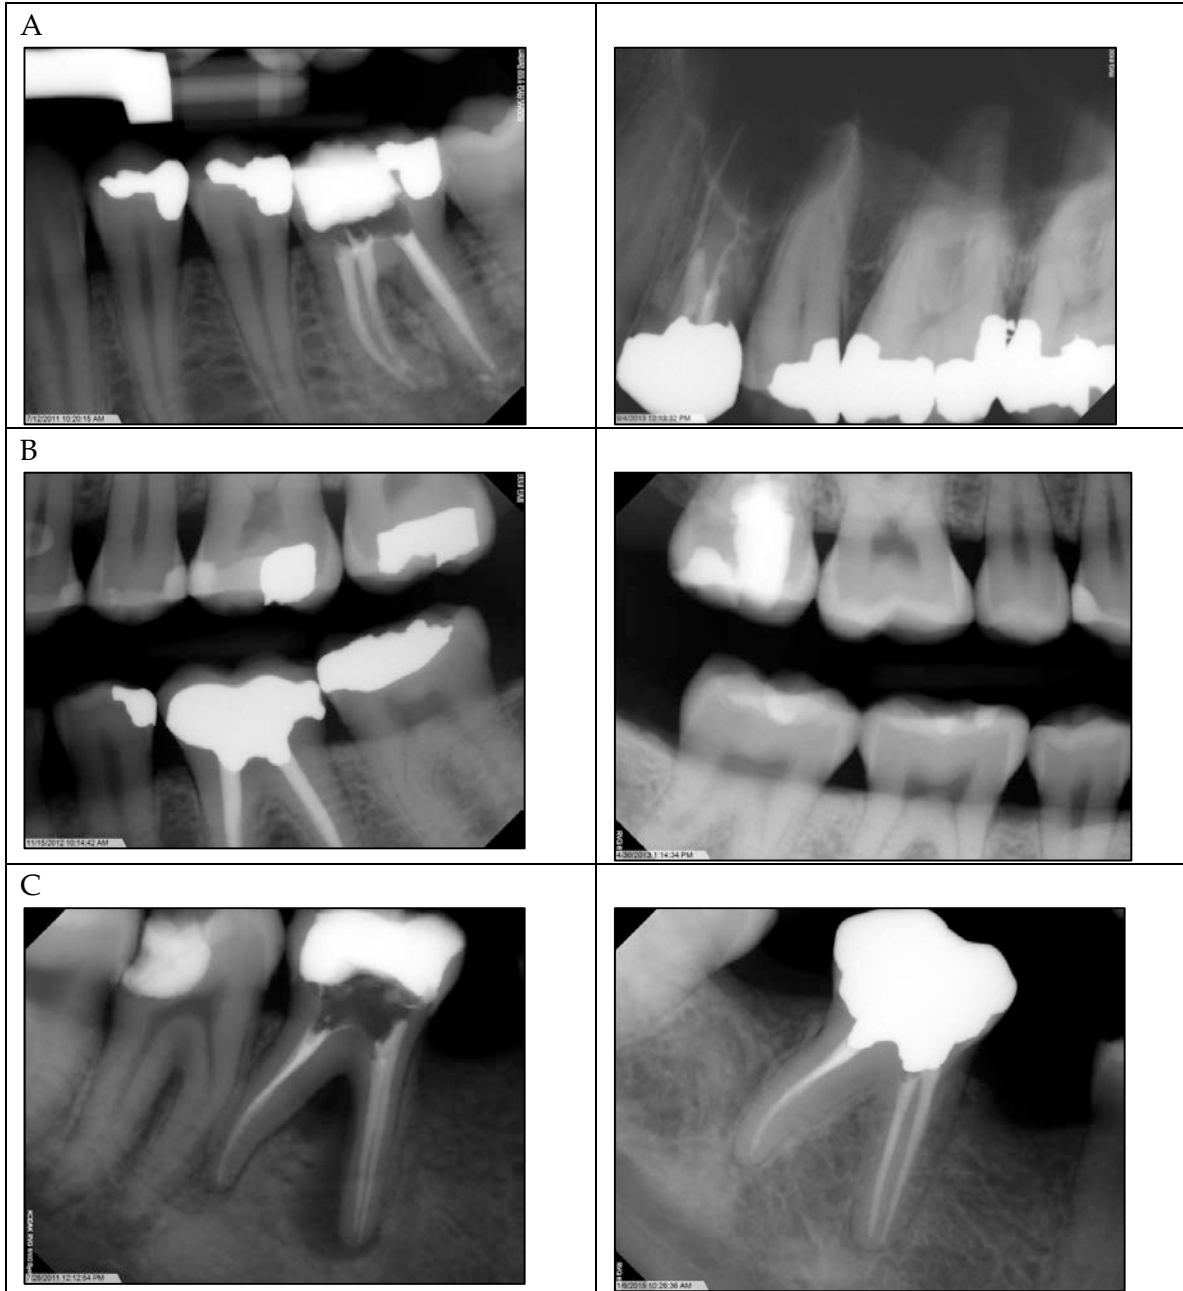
Represents examples of teeth deemed to have (A) adequate (left) and inadequate (right) RCT obturation, (B) adequate (left) and inadequate (right) cuspal coverage restorations, and (C) RCT teeth with periapical pathology present (left) and absent at 42 month recall (right).
